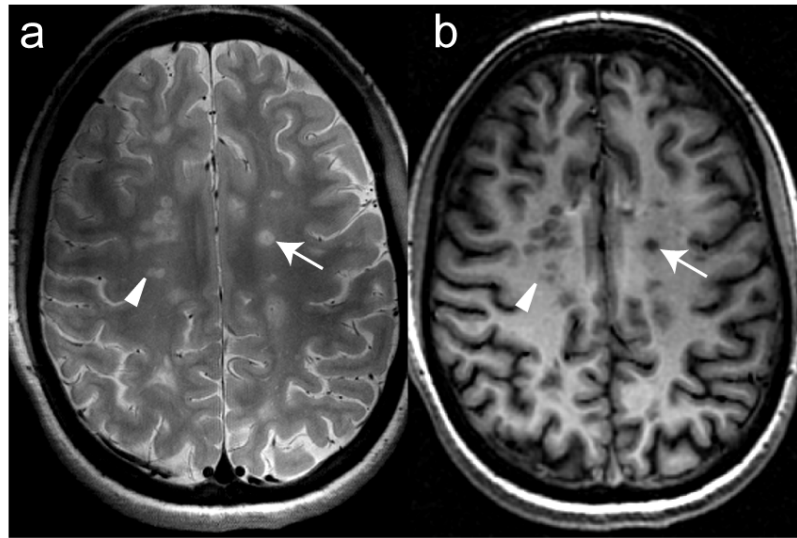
MRI lesion contrast in MS with a)  $T_2$  weighted MRI, b)  $T_1$  weighted MRI (MPRAGE) from 4.7T. Arrow head shows hyperintense  $T_2$  lesions with hypointense  $T_1$  lesion. Arrow shows hyperintense  $T_2$  lesion with hypointense "black hole"  $T_1$  lesion.
